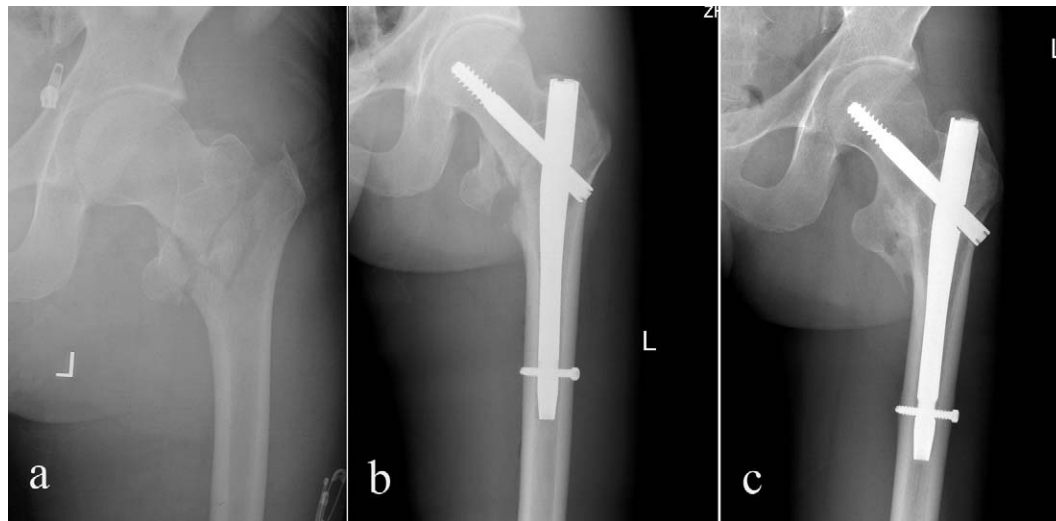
Anteroposterior radiograph showing an unstable proximal femoral fracture of the left hip in a 63-year-old man who fell from his bicycle (a). A TGN device was placed, with the screw inferior in the femoral head (b). Radiograph made 12 months after operation (c), showing a healed fracture.
